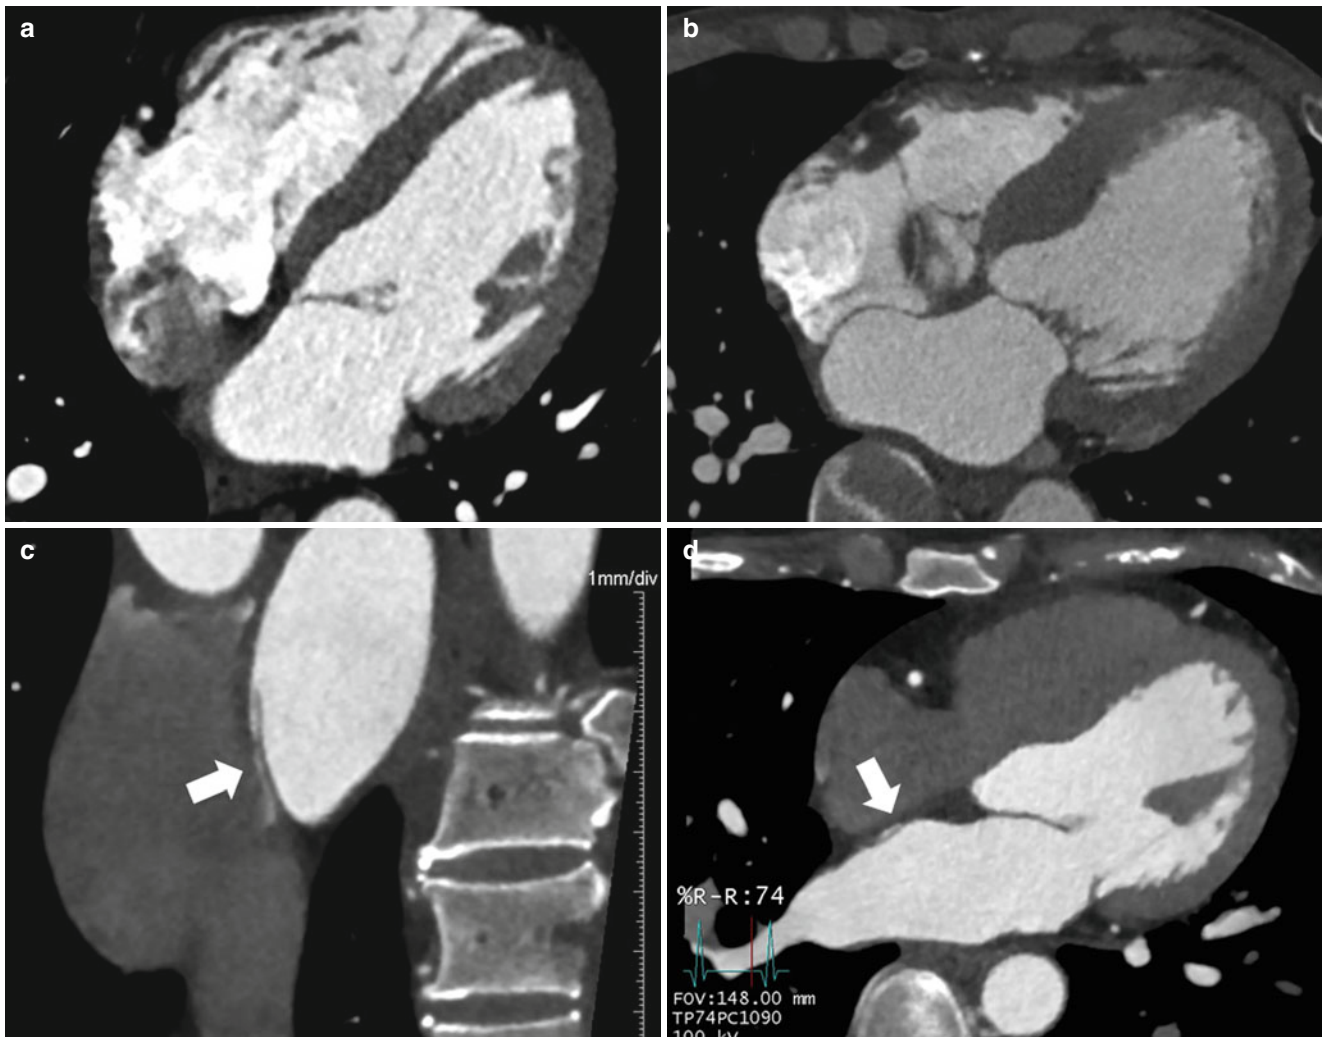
Components of the interatrial septum. Four-chamber view CT images (a, b) show the interatrial groove (*arrow*), eustachian ridge, and muscular atrioventricular septum. The only true septum between the two atria is confined to the area of the oval fossa and a small portion
